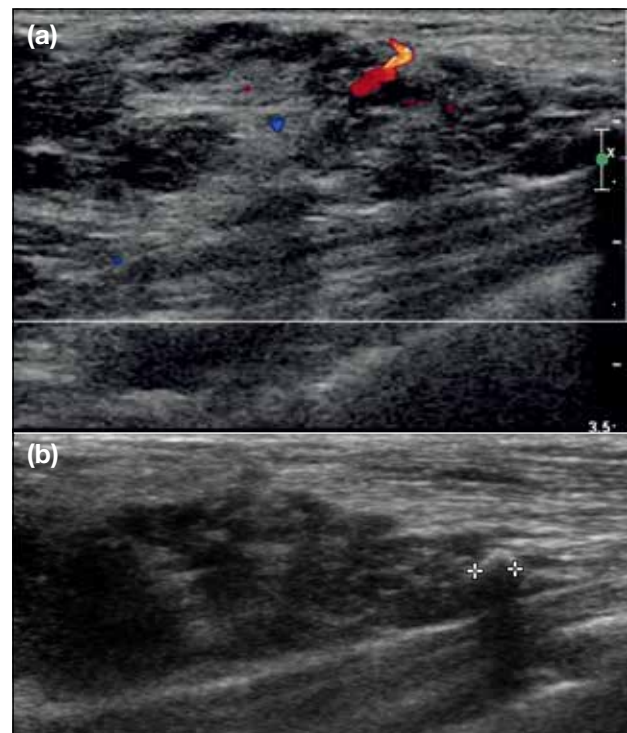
(a, b) Ultrasonogram of the right breast of a 57-year-old woman who presented with an enlarging lump at an old operative site showing a heterogeneous mixed hypoechoic and hyperechoic mass with internal vascularity and calcification, subsequently proven to be a residual haemangioma. She previously had a right breast lumpectomy without prior imaging, pathologically showing a venous haemangioma.
